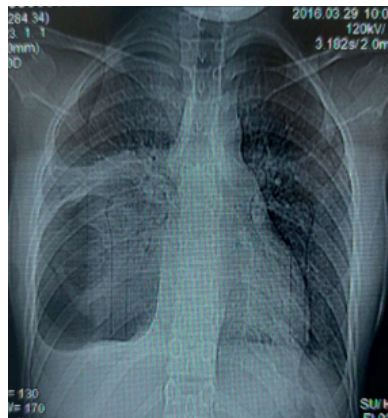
Patient C., 15 years old. Preoperative chest X-ray (explanation in text)
